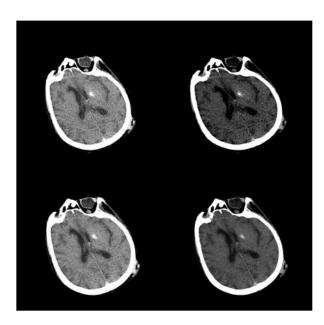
CT scan images of the brain at 100 KV (top) and 120 KV (bottom) with window settings for parenchyma (left) and angiography (right).
